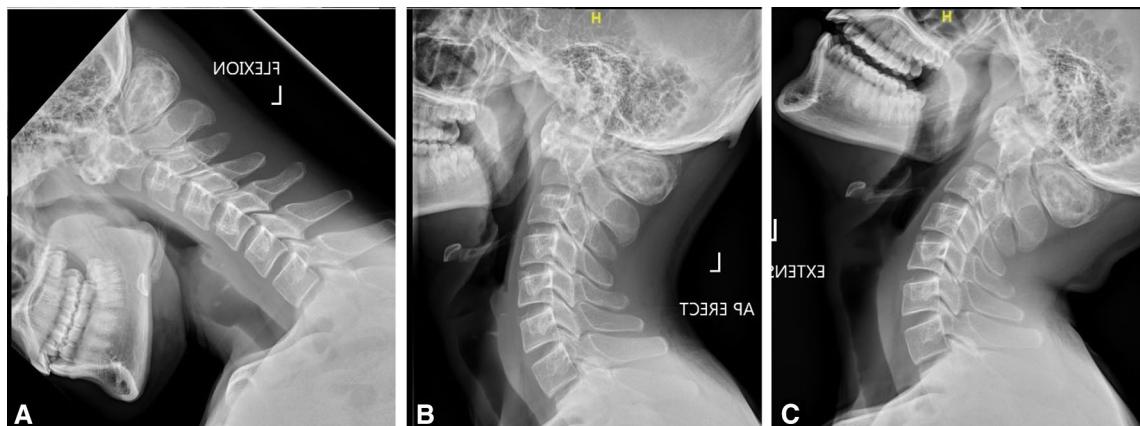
Dynamic lateral radiographs at 12 months of follow-up after completion of denosumab therapy; a flexion view, b neutral view, c extension view
